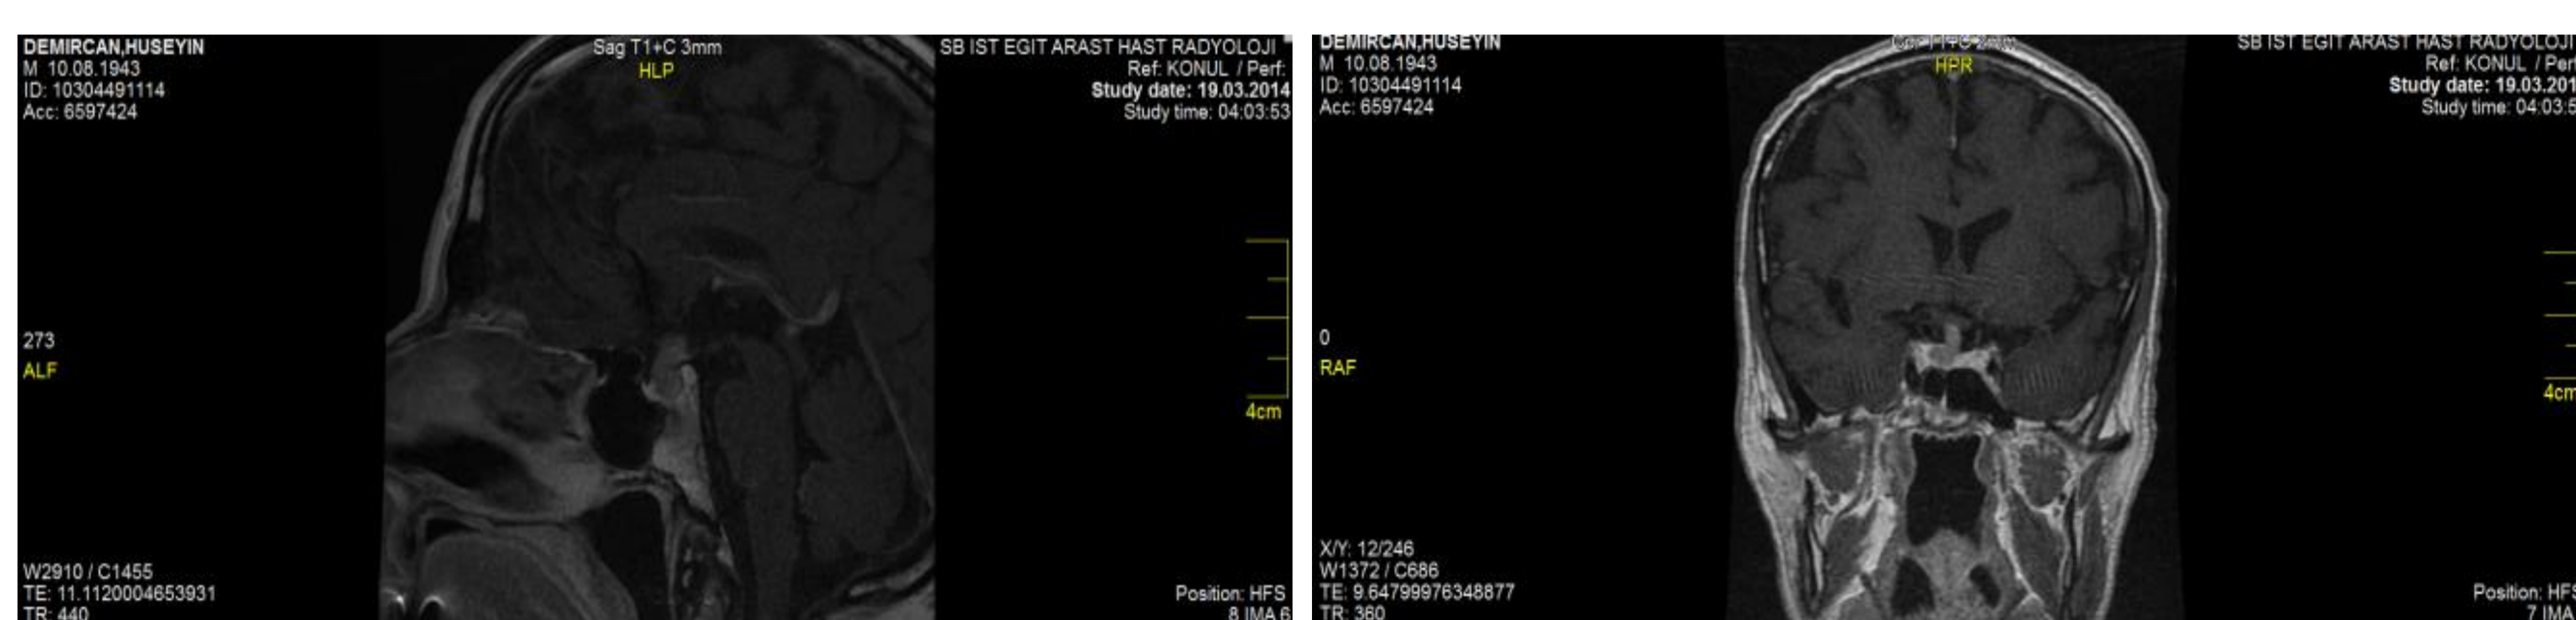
A mass involved stalk and part of the right anterior pituitary on the first MRI
